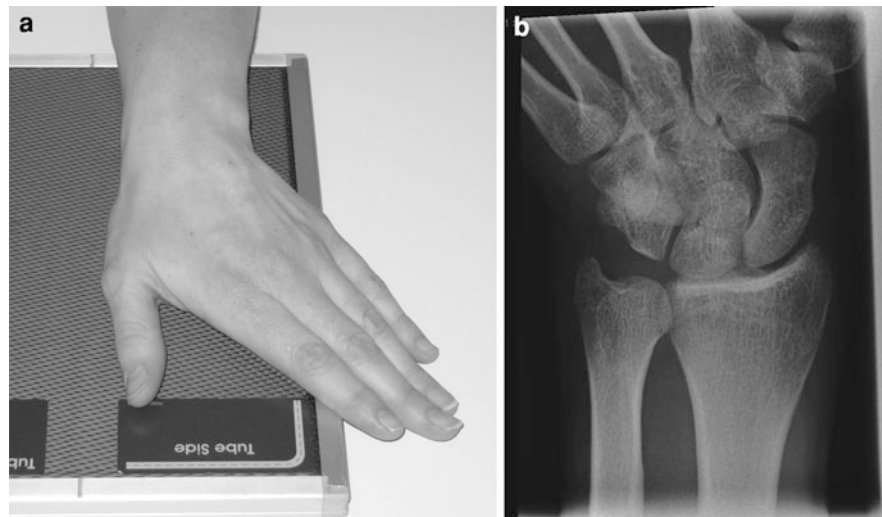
AP radiograph with ulna deviation and 20° of tube angulation
